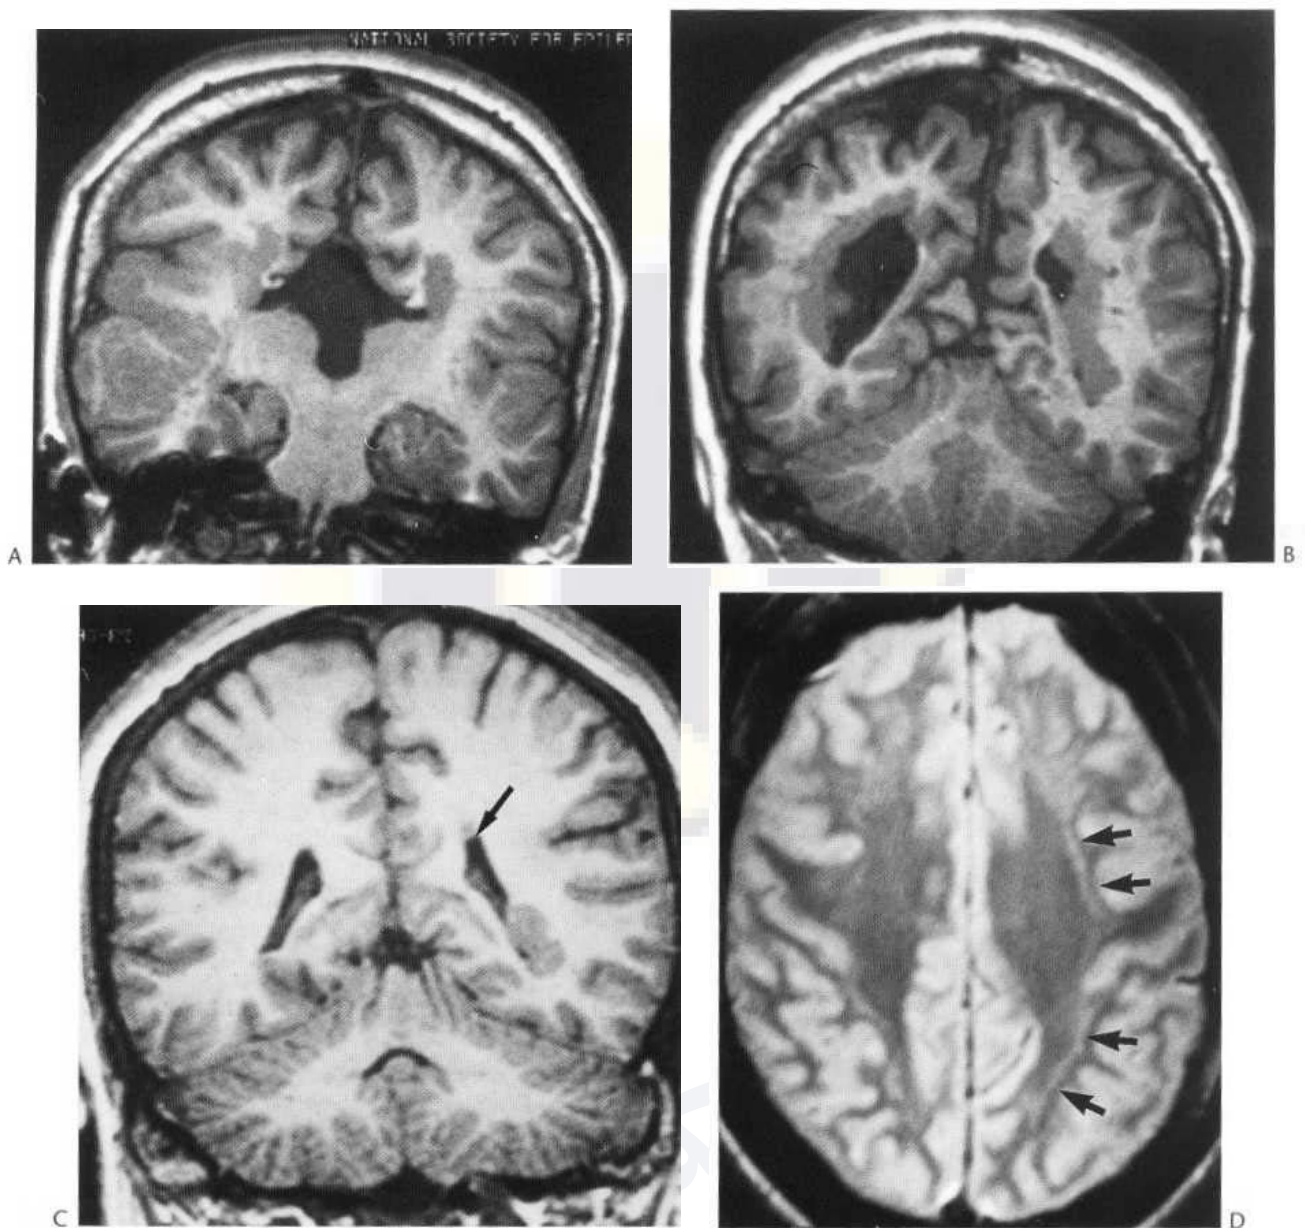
(A) Multiple anomalies including agenesis of corpus callosum, subependymal heterotopia, subcortical heterotopia and polymicrogyria. (B) Diffuse subependymal heterotopia. (C) Unilateral nodular and subependymal heterotopia (arrow). (D) Band-like heterotopic grey matter (arrows) in a patient with epilepsy. Similar but less obvious lesions on right side. Positron density weighted MRI.
